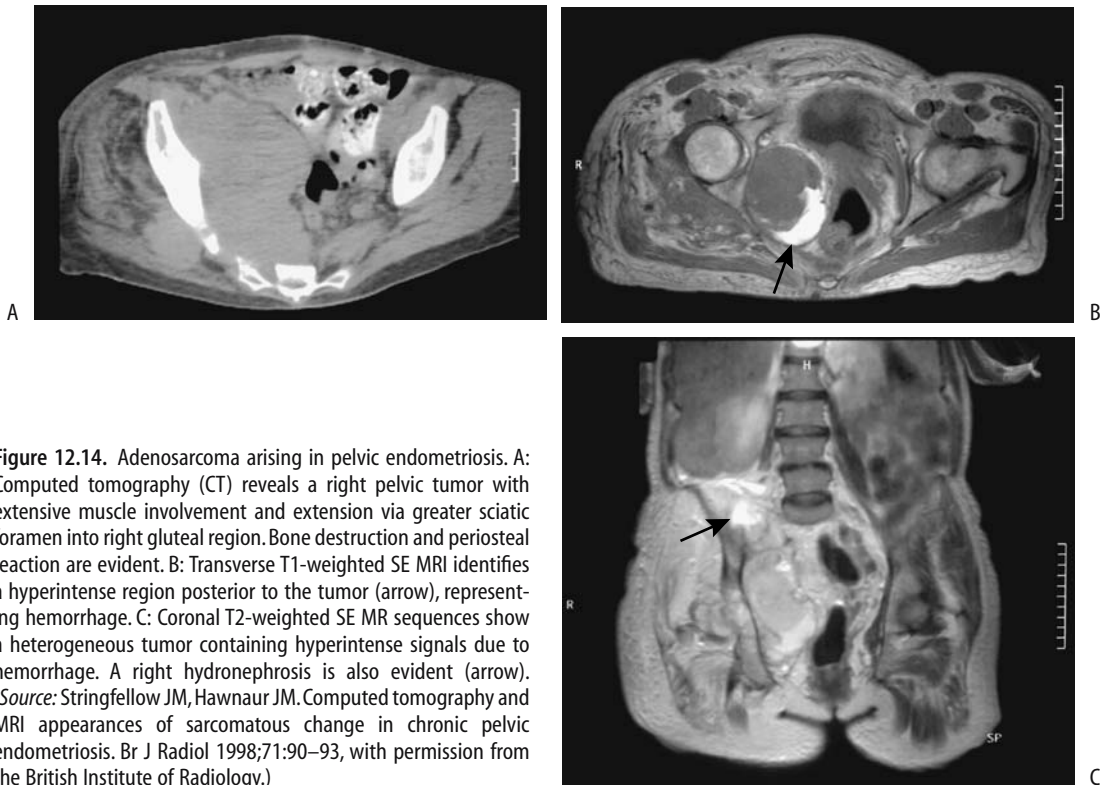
Adenosarcoma arising in pelvic endometriosis. A: Computed tomography (CT) reveals a right pelvic tumor with extensive muscle involvement and extension via greater sciatic foramen into right gluteal region. Bone destruction and periosteal reaction are evident. B: Transverse T1-weighted SE MRI identifies a hyperintense region posterior to the tumor (arrow), representing hemorrhage. C: Coronal T2-weighted SE MR sequences show a heterogeneous tumor containing hyperintense signals due to hemorrhage. A right hydronephrosis is also evident (arrow). (Source: Stringfellow JM, Hawnaur JM. Computed tomography and MRI appearances of sarcomatous change in chronic pelvic endometriosis. *Br J Radiol* 1998;71:90–93, with permission from the British Institute of Radiology.)
